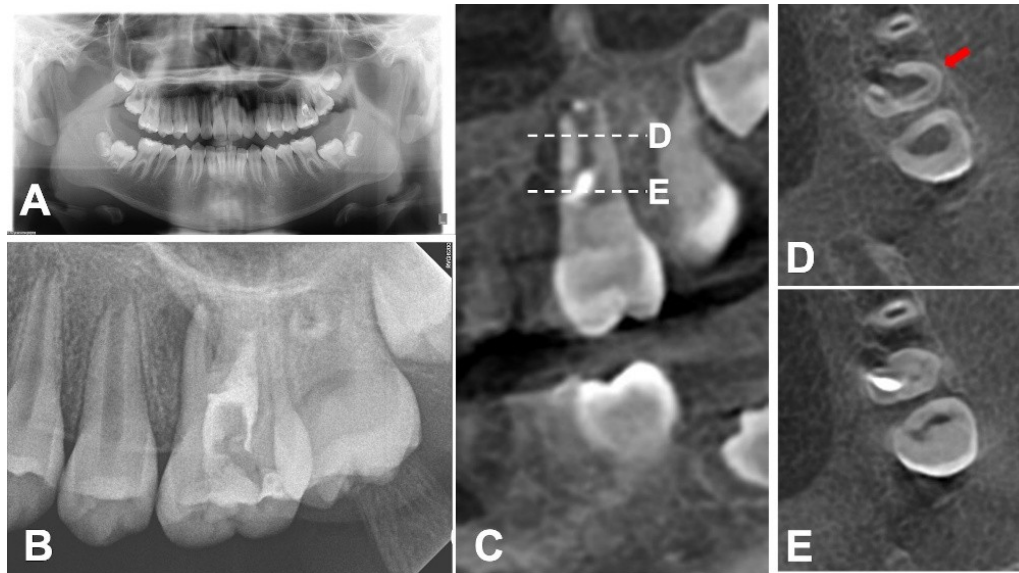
Preoperative Radiographs. (A) Panoramic radiograph and periapical radiograph showing the previously initiated endodontic treatment on tooth #26. (B) The palatal root has an immature, open apex. (C) Sagittal CBCT view of the maxillary molar. Dashed lines D and E indicate the respective levels of the apical and coronal axial image. (D) Axial CBCT image (apical area). The red arrow points to the fused morphology of the mesiobuccal (MB), distobuccal (DB), and palatal (P) root. (E) Axial CBCT image (coronal area).
